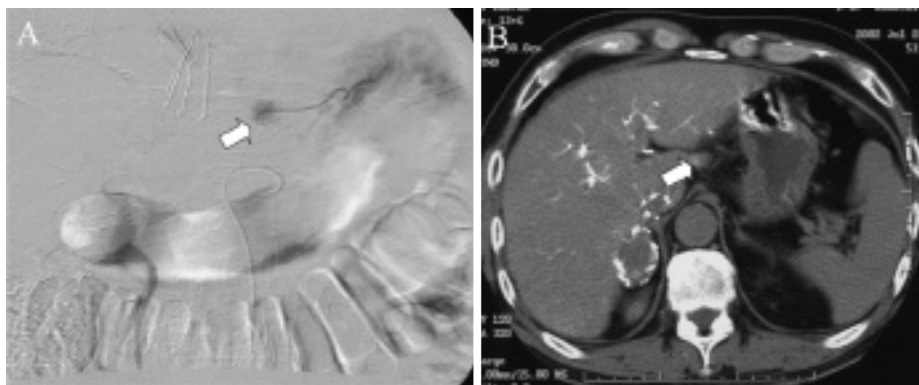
A: A tumor (arrow) seen in a lymph node along the lesser curvature of the stomach on an arteriogram of a feeding vessel from the left gastric artery; B: An enlarged lymph node (arrow) observed along the lesser curvature of the stomach on computed tomography during a hepatic arteriogram of the common hepatic artery.
